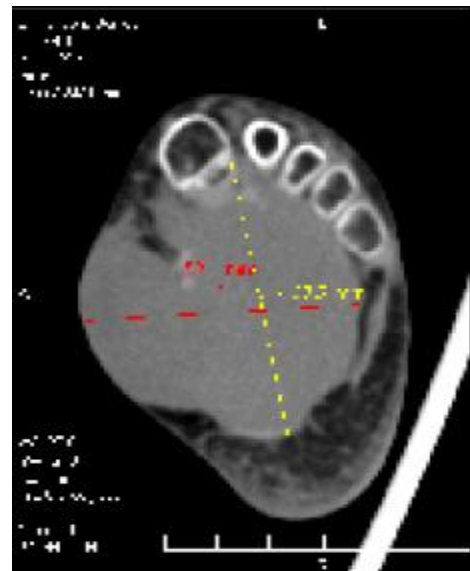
Embryonal RMS. CT image show large homogeneous soft tissue mass involving whole plantar area
